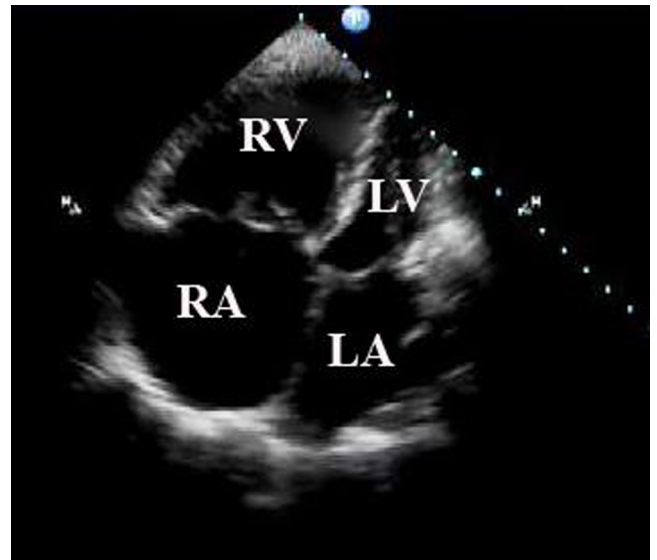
Right ventricular dilatation (right ventricle:left ventricle ratio >1:1) in this apical 4-chamber image of a patient with an acute pulmonary embolism. RV, right ventricle; LV, left ventricle; RA, right atrium; LA, left atrium.
